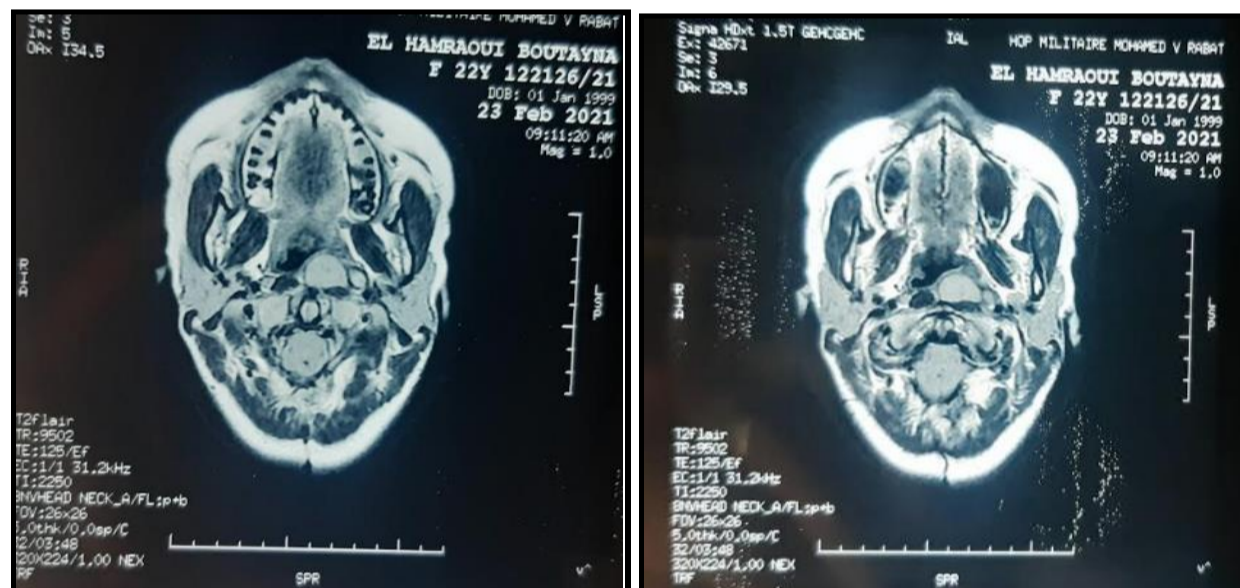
axial sections of a cervical MRI showing the retropharyngeal abscess in T1 and T2
